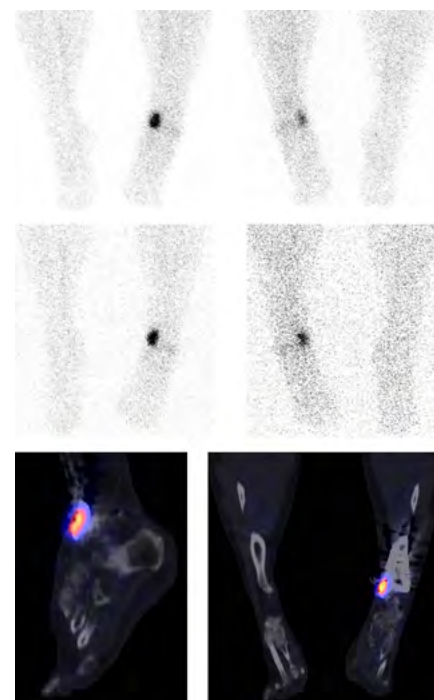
WBC scintigraphy (upper row: delayed images (4 h after injection of the radiolabelled cells) anterior and posterior views, middle row: late images (24 h after injection) anterior and posterior views, lower row: fused SPECT/CT images. The planar images (corrected for decay and showed in counts intensity) show high focal uptake, increasing over time, suspected infection. The SPECT-CT images show that the infection is located at the metallic implant in the medial malleolus.
